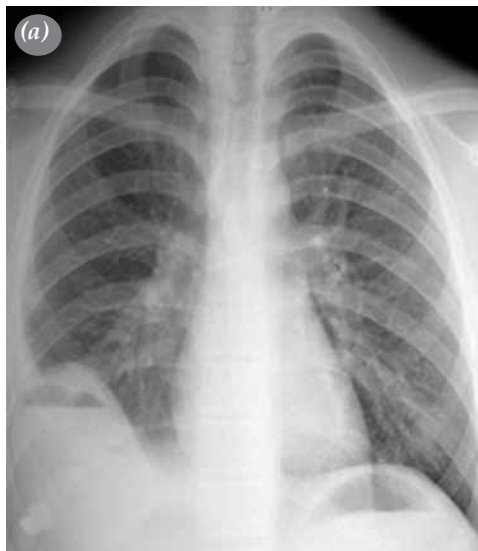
(a) Direct posteroanterior lung X-ray of the third case showing the air-fluid level. The right diaphragm contours are erased. (b) Computed tomographic image of the third case showing a lesion measuring approximately 8 cm in diameter at the posterobasal portion of the lower lobe of the right lung along with thick-walled abscesses containing internal air densities and the air-fluid level. Minimal pleural effusion is present where the right diaphragm contour was erased.
